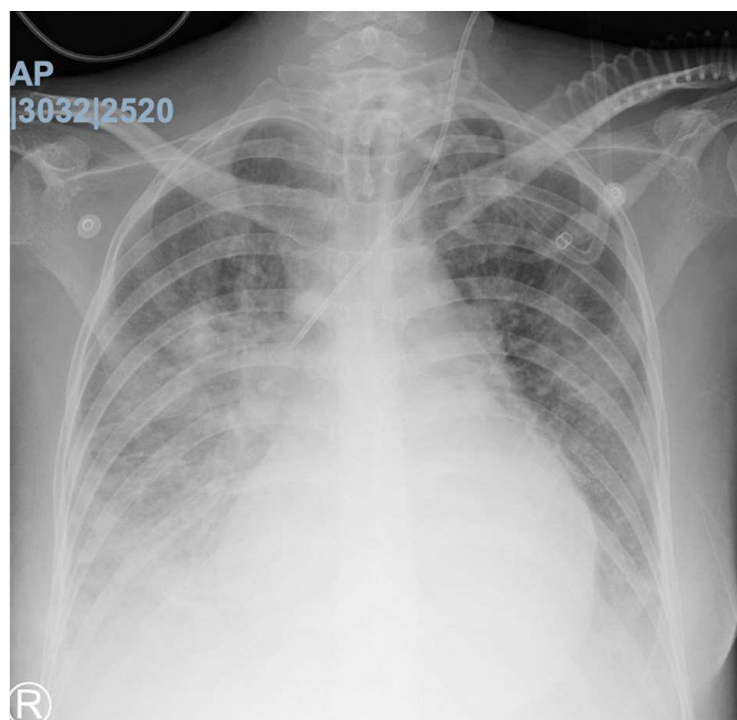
Chest X-ray showed cardiomegaly, pneumonia, and bilateral pleural effusion.
